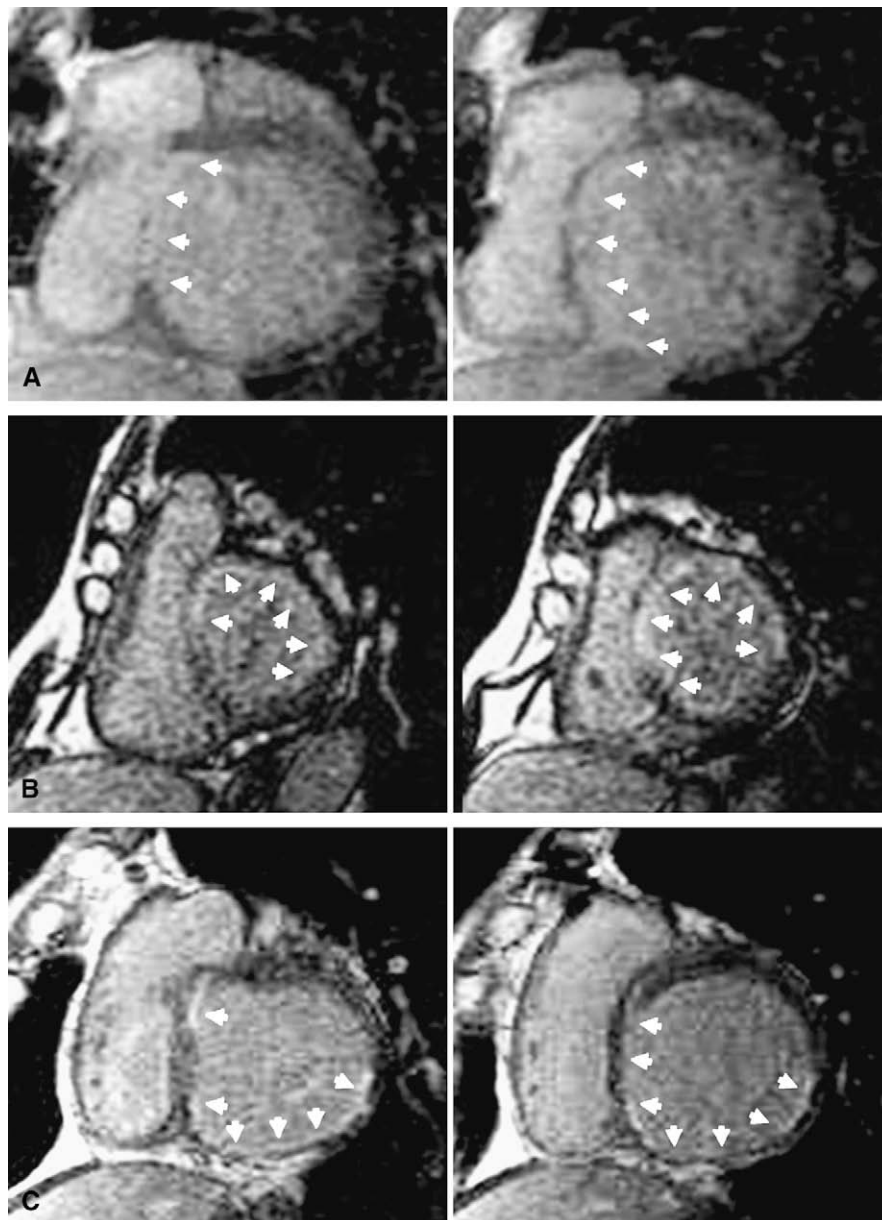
Representative short-axis delayed-enhancement magnetic resonance images of left ventricular base in patients with anteroseptal infarction (A), anteroseptal with posterolateral infarction (B), and anteroseptal with inferoposterior infarction (C). Myocardial scarring was clearly identified as hyperenhancement region (arrow).
